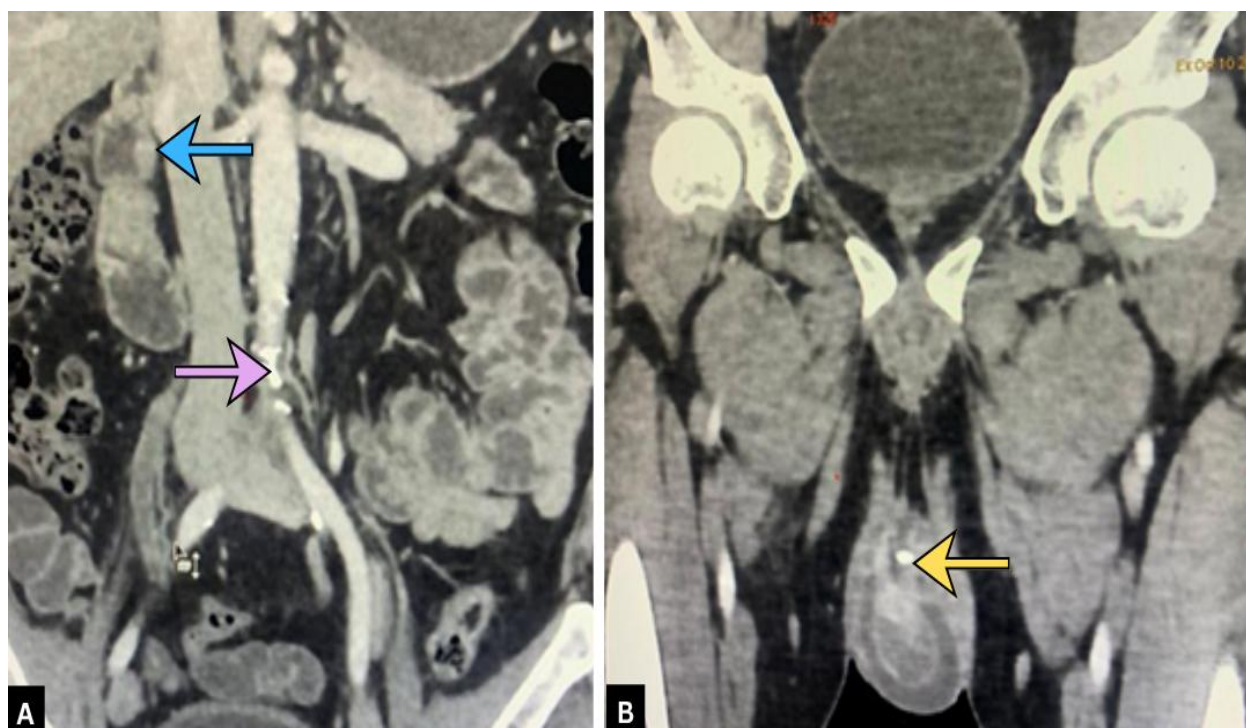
A-B CT abdomen - pyelitis with urethritis, solid cystic areas, areas of calcification replacing the scrotal sac.
